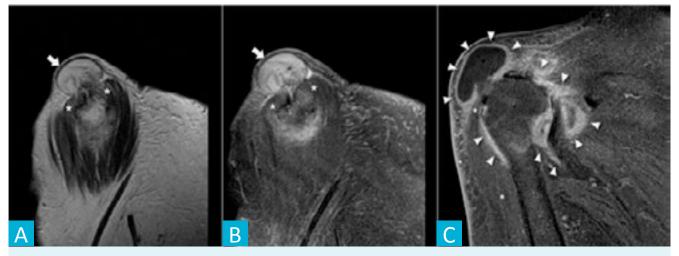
Pseudo-geyser. Sagital T2w weighted (A) and sagital T2w fat-saturated (B) MR images depicting the pseudo-geyser [arrow] protruding through a full thickness tear near the proximal insertion of the deltoid [asterisk]. Coronal T1w fat-saturated MR image after intravascular administration of gadolinium (C) showing the hyper-enhancement of the pseudo-geyser wall and the articular capsule, corresponding to the inflammatory/ infectious reaction.
